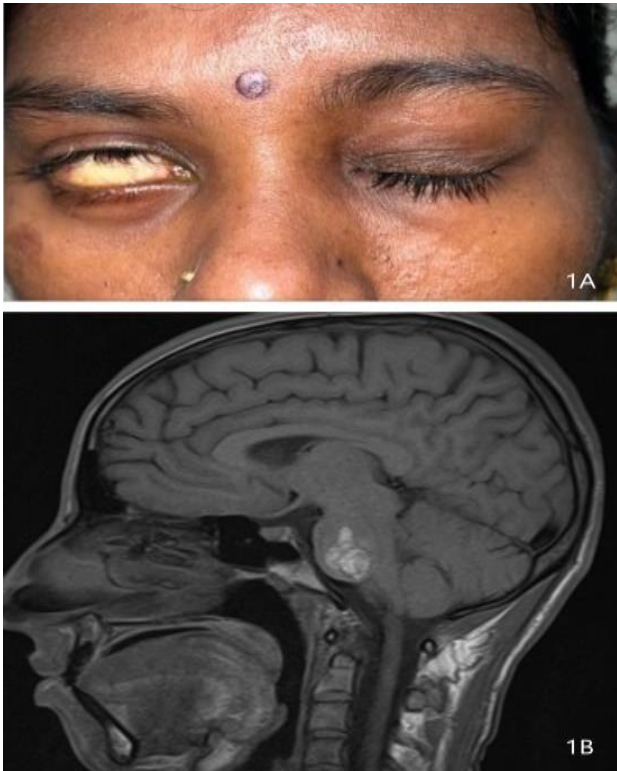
(A and B): Clinical photograph of patient showing right side inadequate lid closure due to facial nerve palsy. Sagittal view of MRI brain of well-defined hypertense lesion in brainstem (Cavernoma).
